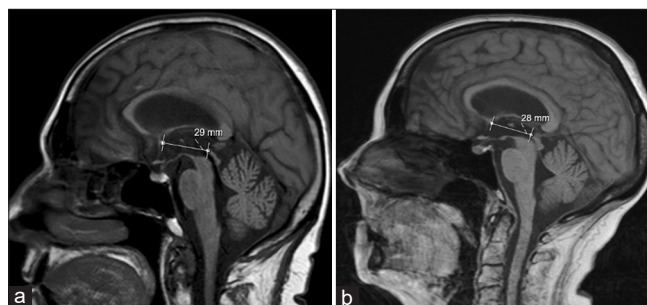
Preoperative sagittal T1 magnetic resonance imaging displaying an increased anterior and posterior commissure line in (a) patient 1 - 28.6 mm and (b) patient 2 - 28.0 mm.
